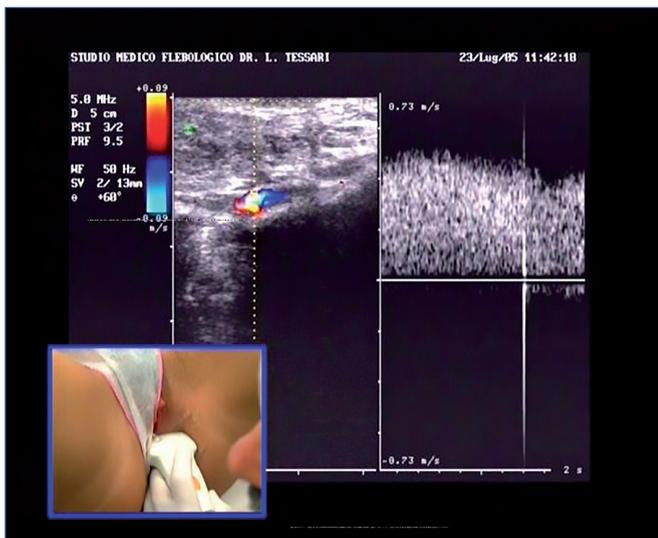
Sonographic evaluation of pelvic reflux evoked by a Valsalva maneuver.
